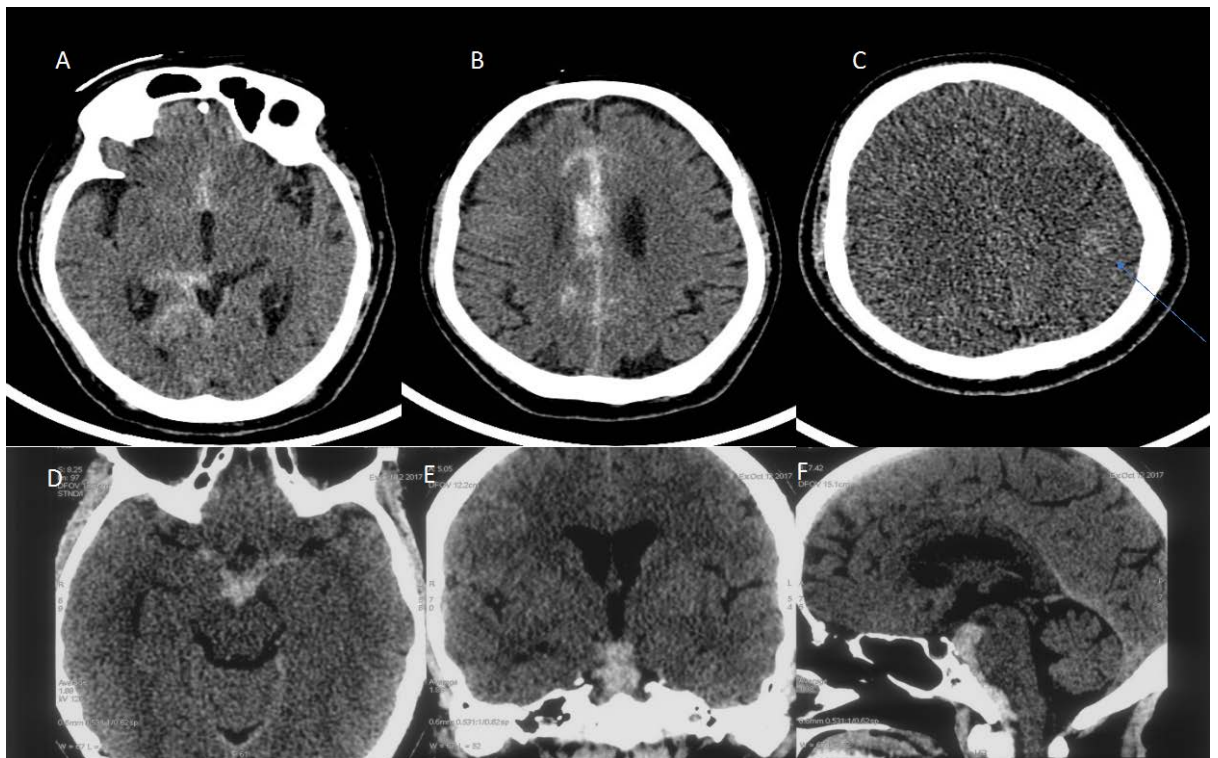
A & B CT head images showing diffuse SAH, more in interhemispheric fissure; C shows left parietal convexity SAH (arrow) with diffuse cerebral oedema; D, E & F are axial, coronal and sagittal cuts showing PMH variant of SAH
